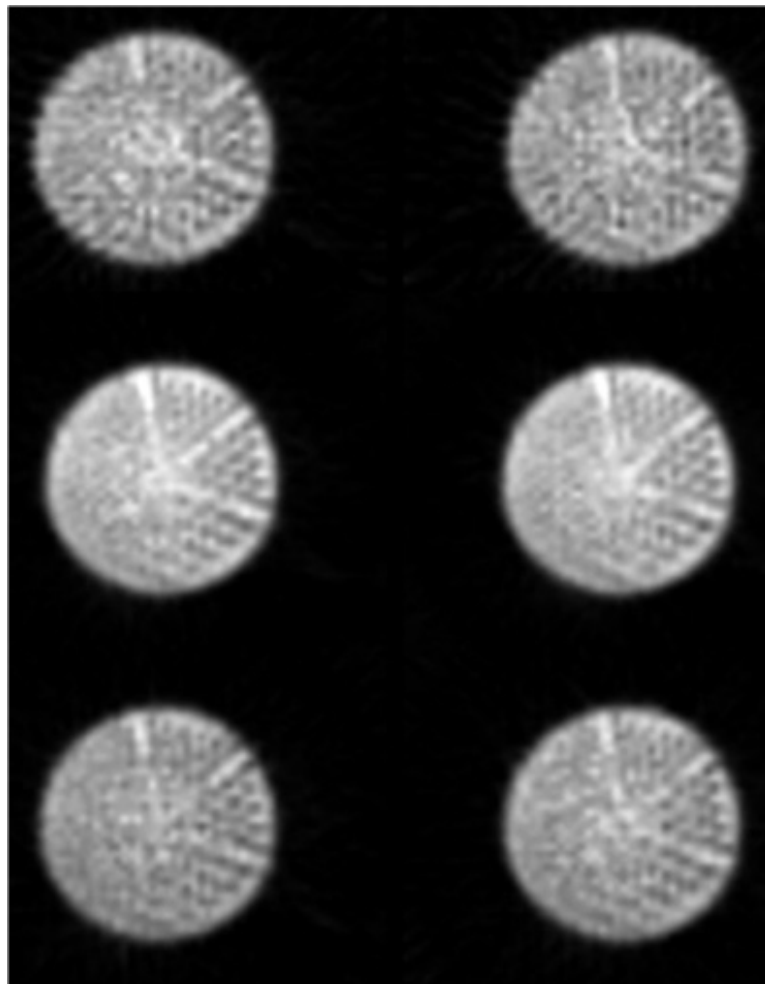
Rods section slices obtained with a dedicated cardiac SPECT scanner (90 degree detector configuration, using a 180 degree arc acquisition from LPO to RAO) reconstructed with FBP and Chang-AC: (top row) 32×32 , 32 projections; (middle row) 64×64 , 64 projections; (bottom row) 128×128 , 64 projections.
